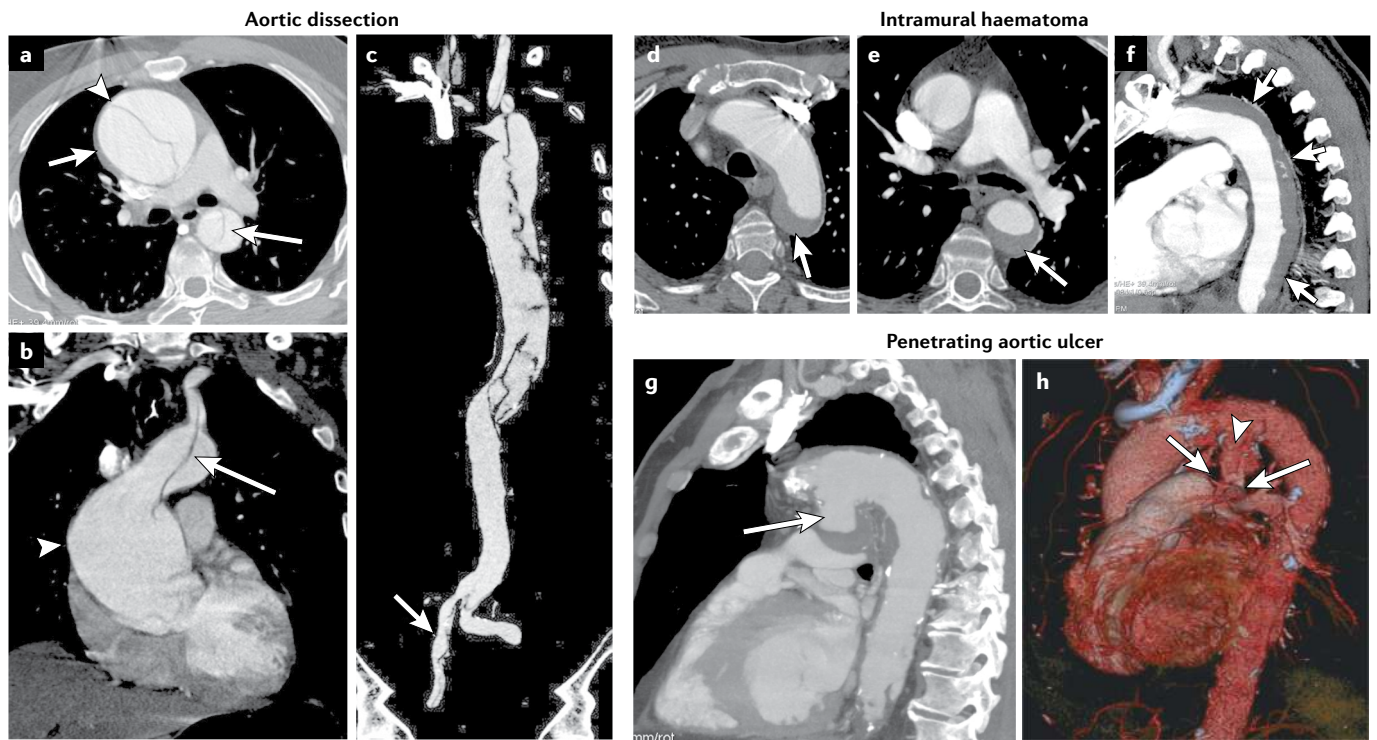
Imaging of acute aortic syndromes. a | Aortic dissection. Axial contrast-enhanced CT image showing an ascending thoracic aortic aneurysm (TAA; arrowhead) complicated by a type A dissection (arrows) caused by elastic tissue dystrophy in a patient with Marfan syndrome. b | Coronal contrast-enhanced CT reconstruction showing an ascending TAA (arrowhead) with an intimal dissection (arrow) that extends into the anonymous trunk lumen in a patient with Marfan syndrome. c | Coronal contrast-enhanced CT reconstruction showing an intimal flap inside the aortic lumen that extends into the common right iliac artery lumen (arrow). d | Intramural haematoma. Axial contrast-enhanced CT image showing a thoracic aortic arch haematoma with intramural blood collection (arrow).
